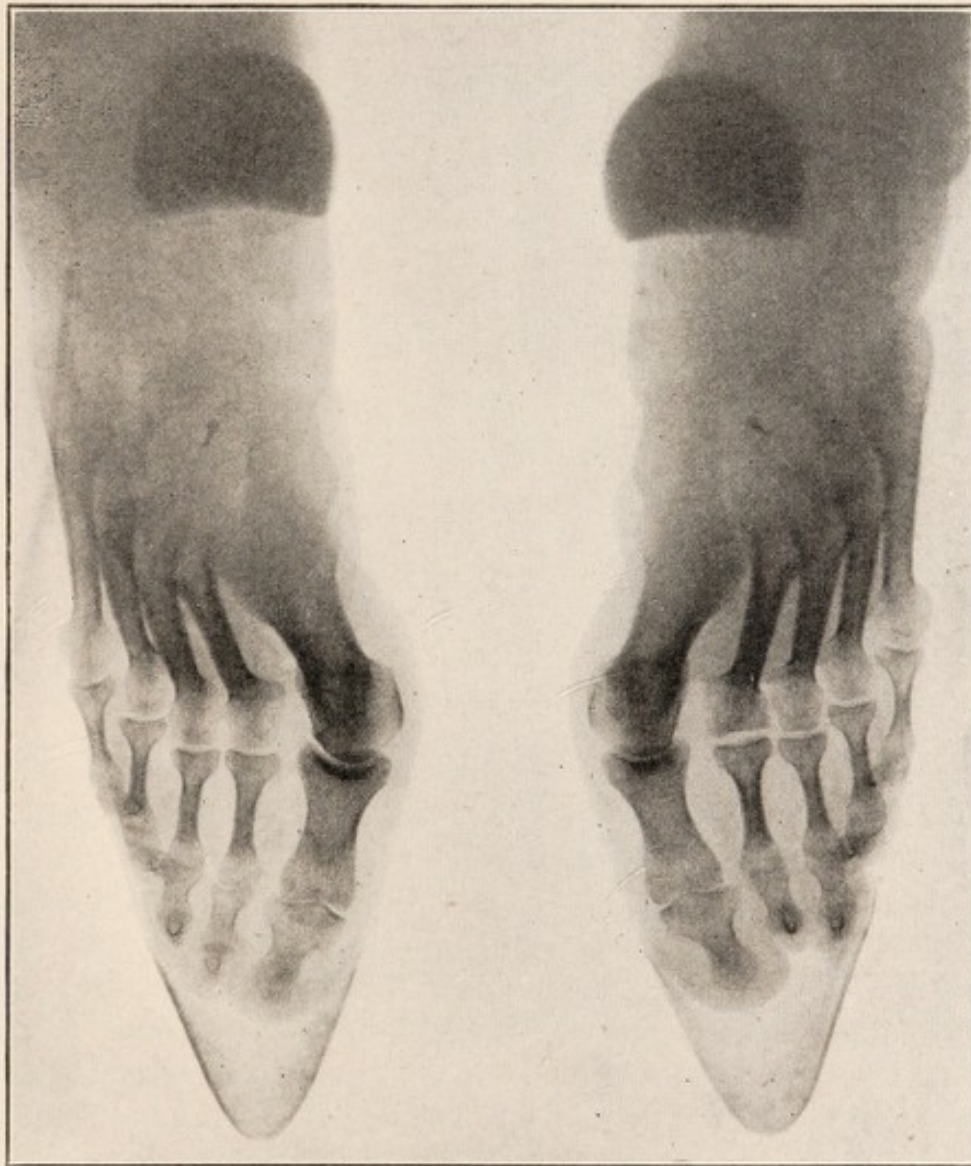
X-ray of Fig. 452 showing deformity produced.
